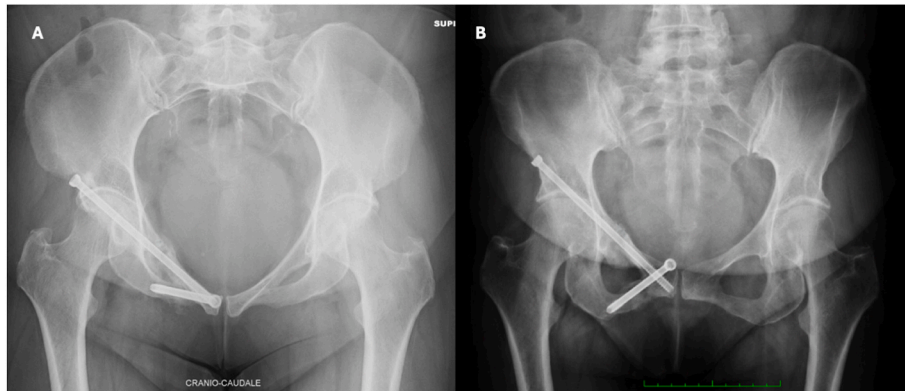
X-Ray assessment at 6 months of follow-up. A. Outlet view. B. Inlet view.
